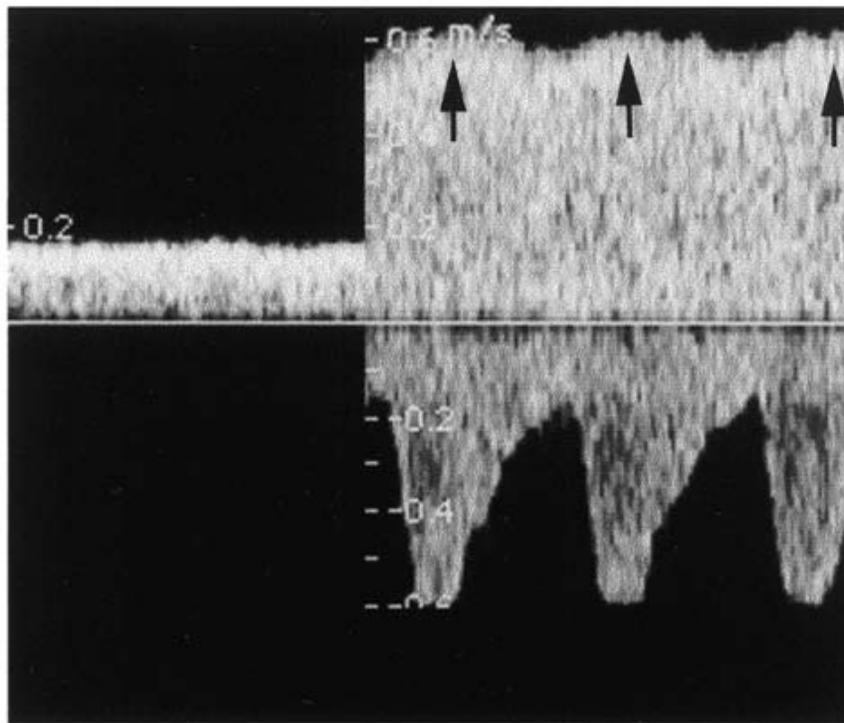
Doppler recording of the blood velocity at the inlet of the ductus venosus in a normal fetus at 34 weeks of gestation. The fetal position has caused a squeezing of the ductus venosus outlet (cf. Figure 14 c) (upper panel). A few minutes later the pulsatile flow is being restored with the change of fetal position (lower panel). Printed with permission<sup>118</sup>
